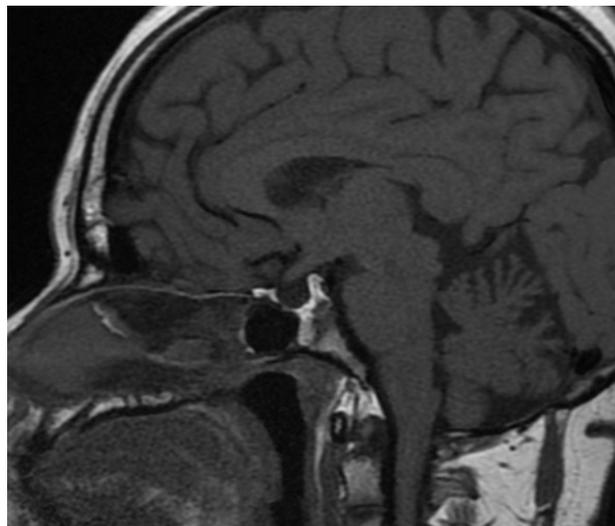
Sagittal Magnetic Resonance Imaging (MRI) of the patient's skull, showing the presence of CSF at the sella turcica.
